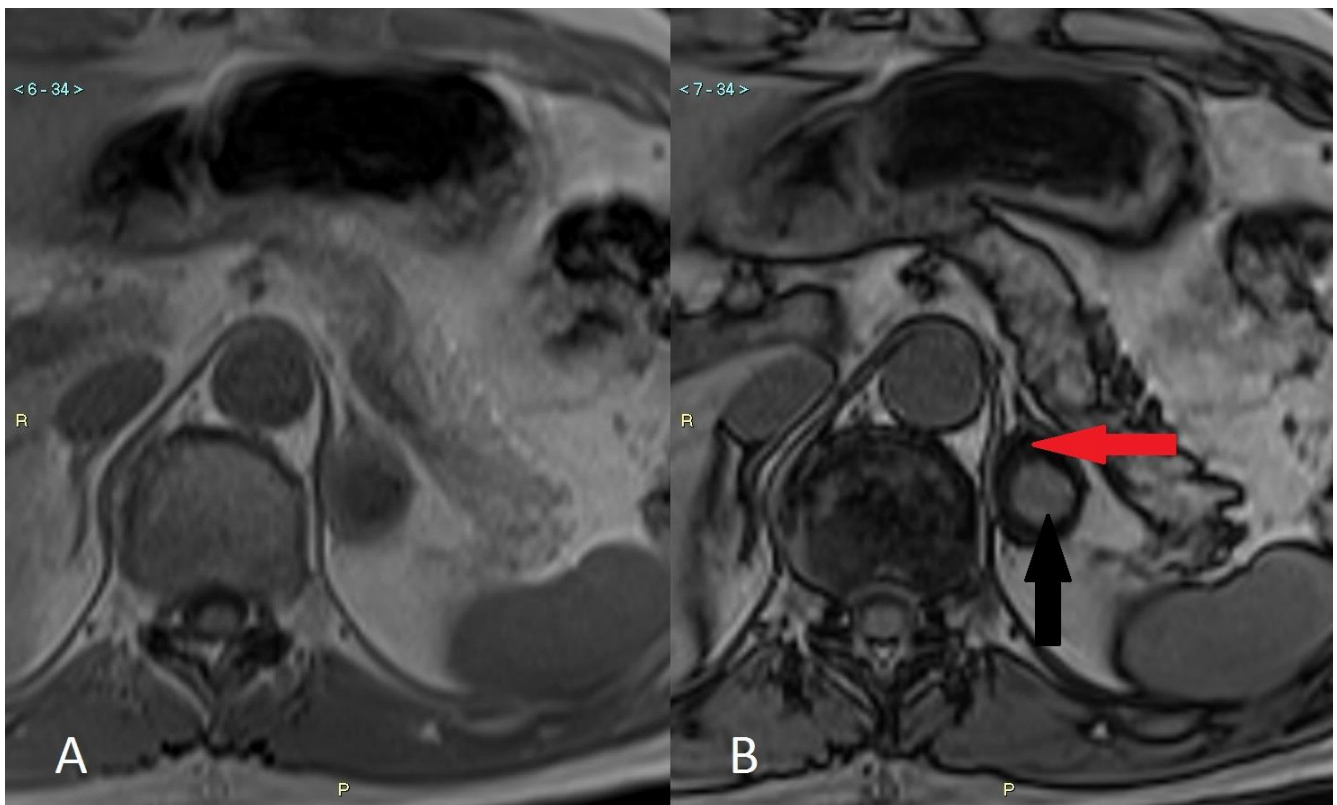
A 63-year-old man with an adenoma-hemangioma adrenal collision tumor. 2018 Magnetic Resonance Imaging (follow up exam after 24 months).
